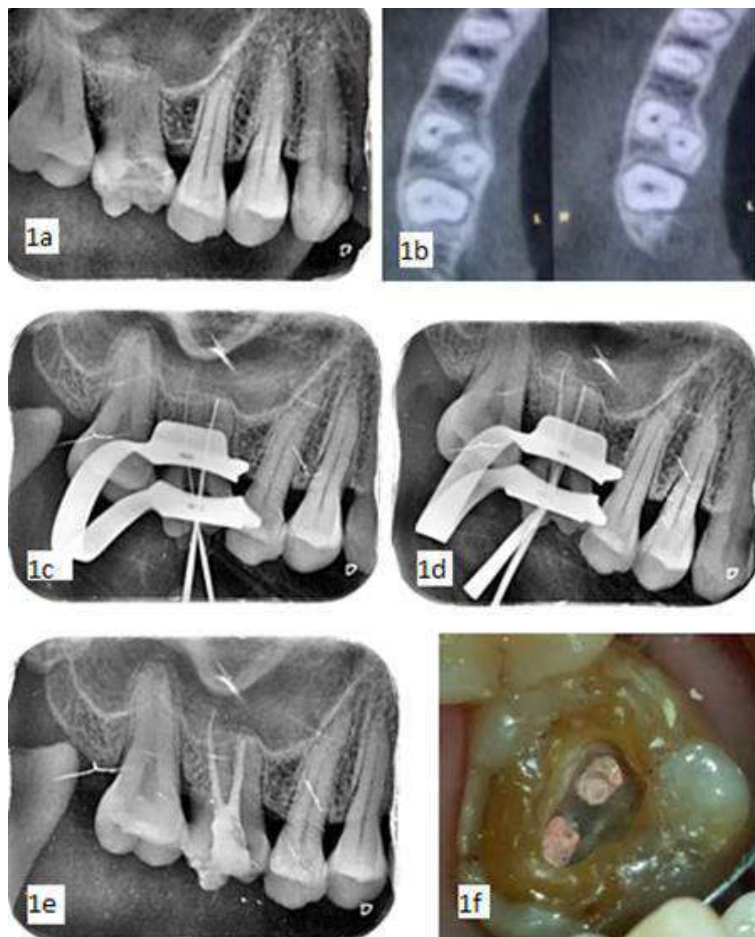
1a. Preoperative periapical radiograph, 1b. CBCT axial plane, 1c. Working length determination, 1d. Master cone selection, 1e. Post-obturation radiograph, 1f. Clinical image showing two canal orifices
